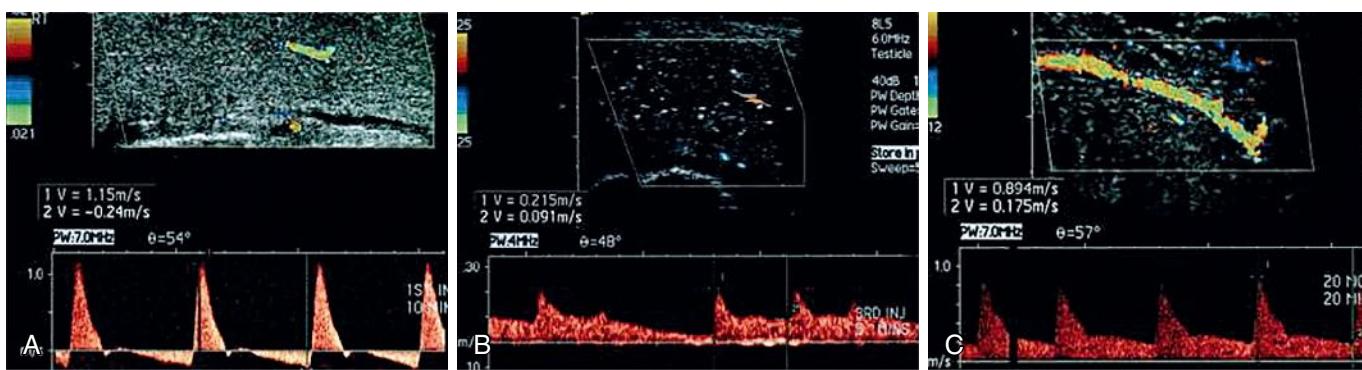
Color Doppler Duplex Ultrasound of the Penis. (A) Normal erectile hemodynamics: Doppler waveform analysis demonstrating cavernosal artery peak systolic velocity of 115 cm/s and end-diastolic velocity of -24 cm/s, representing normal erectile hemodynamics. (B) Mixed vasculogenic erectile dysfunction (ED): Doppler waveform analysis demonstrating cavernosal artery peak systolic velocity of 21.5 cm/s and end-diastolic velocity of 9.1 cm/s, indicating the presence of arterial insufficiency and corporal veno-occlusive dysfunction (CVOD). (C) Corporal veno-occlusive dysfunction: Doppler waveform analysis demonstrating cavernosal artery peak systolic velocity of 89.4 cm/s, and end-diastolic velocity of 17.5 cm/s. End-diastolic velocity greater than 6 cm/s indicates corporal veno-occlusive dysfunction. (Source: Wilkins CJ, Sripasad S, Sidhu PS. Colour Doppler ultrasound of the penis. *Clin Radiol.* 2003;58(7):514–523.)
